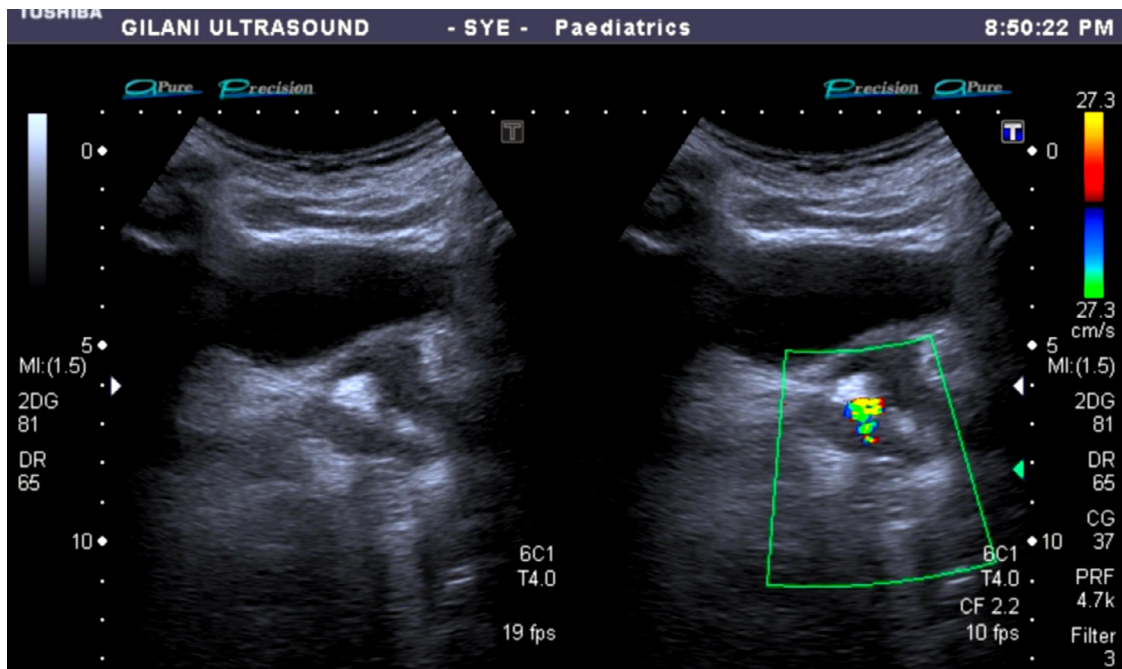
A stone in the prostatic part of the urethra has a faint shadow because of its position adjacent to strong reflectors (gases in the rectum posterior to the stone), but color Doppler twinkling artifact is able to recognize it.
